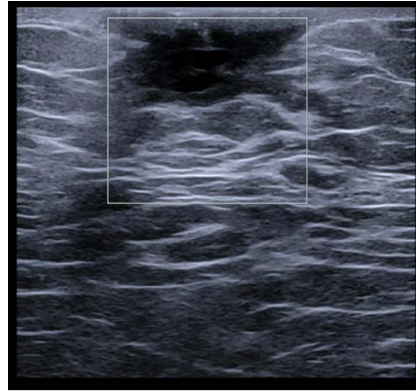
Targeted ultrasound of the left subareolar area demonstrated a fluid collection concerning for abscess.
